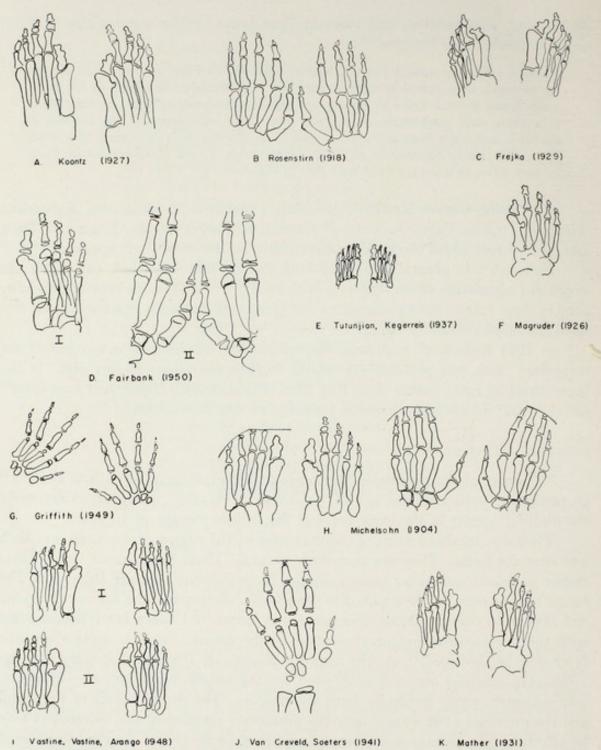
Tracings of x-ray films of hands and feet in selected reported cases (these are not reproduced to the same scale). A, Koontz²⁵: Hands little affected. In feet, monophalangic first digit and biphalangic fifth digit. On the right the fourth toe is also biphalangic. There is an exostosis on the right great toe and bone bridge between metatarsals on the left. B, Rosenstirn¹⁰: The short, pointed terminal phalanx of the thumb is typical. The first metacarpal on the left is abnormal in shape. (Frequently the first metacarpal and metatarsal has a disorganized trabecular pattern.) The terminal phalanges of the other digits, especially the second and third, also short and pointed. C, Frejkaⁿ: The fingers were not commented on. The first toe is monophalangic and the others biphalangic at the most. Typical hallux valgus is present. D, Fairbank7: 1, 7 years of age. First metatarsal appears to have been lengthened by fusion with the proximal phalanx. The other toes are all biphalangeal. II, 10 years of age. The character-istic short, pointed terminal phalanx is seen. There was also microdactyly of the great toes. E, Tutunjian and Kegerreis⁴⁸: No comment on the state of the hands. It is interesting to note that monophalangic first toe can be present without microdactyly or hallux valgus. F, Magruder²⁹:
